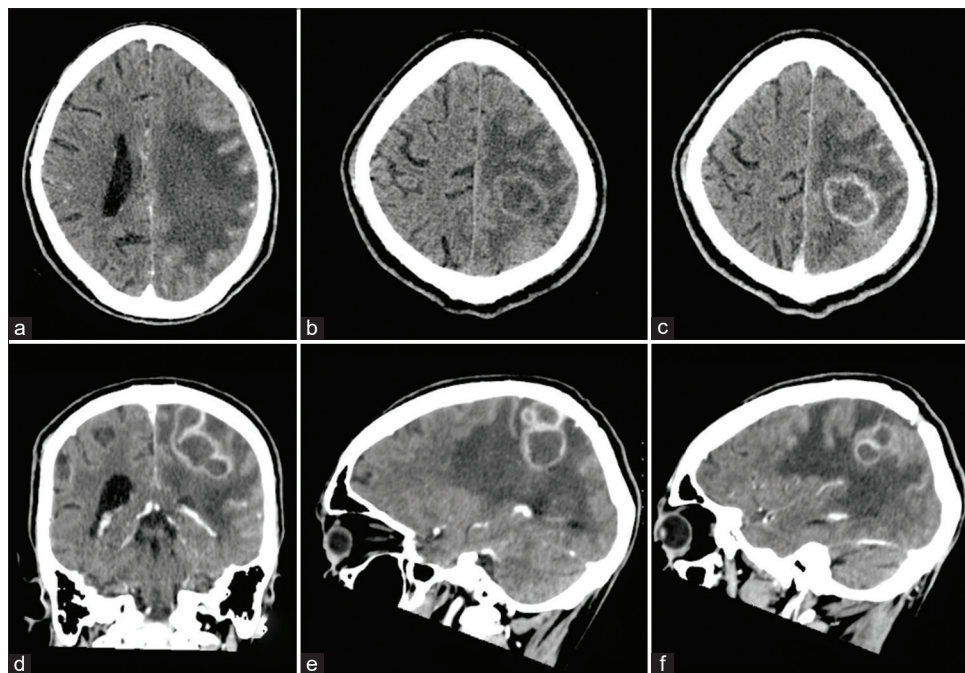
Computed tomography scan before (a and b) and after (c-f) contrast injection. Significant perilesional edema and isodense peripheral aspect of multinodular subcortical left parietal lesion with hypodense content to normal parenchyma with moderate mass effect to the left lateral ventricle (a and b). Ring peripheral postcontrast enhancement in axial, coronal, and sagittal views (d-f).
